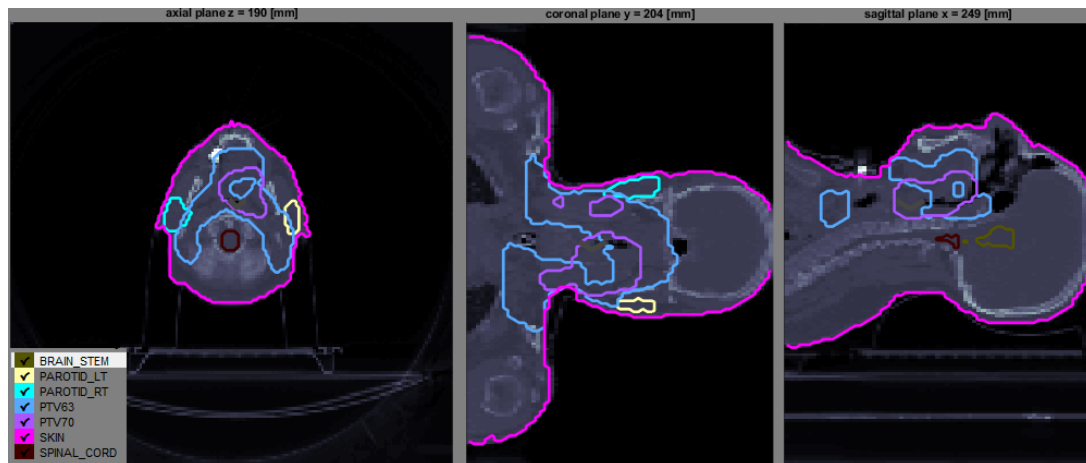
Delineated structures in a CT scan on 3 planes (axial, coronal and sagittal). In this image it is possible to see several delineated structures, namely two PTVs with different dose requirements, the spinal cord, parotids and brainstem.
